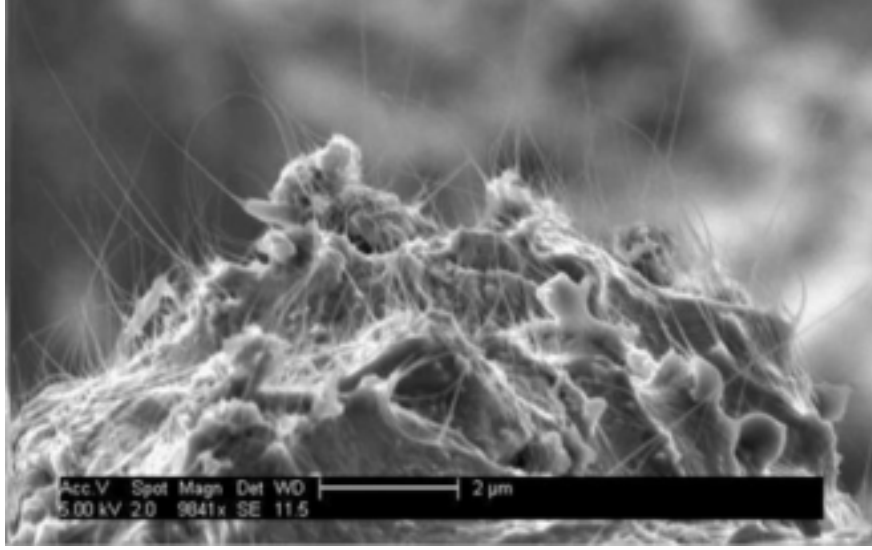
SEM image of a CNT cathode typically used in CNT x-ray sources.
